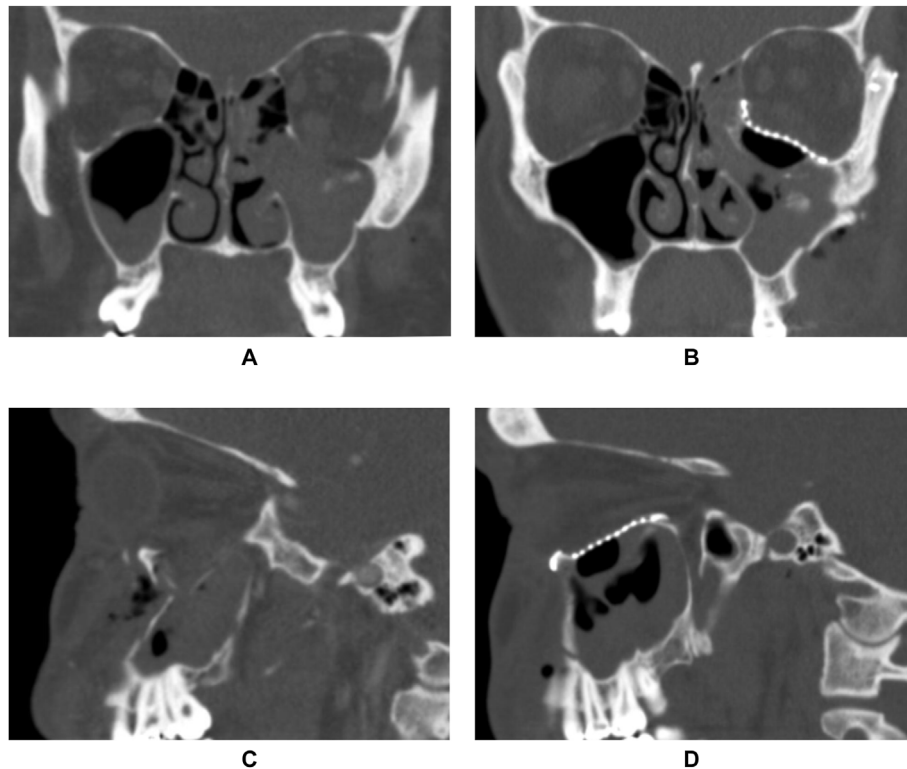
Computed tomography images of a patient treated with patient-specific milled implants.
